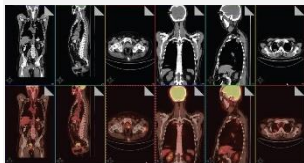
Whole body positron emission tomography/computed tomography (PET/CT) coronal and lateral images and transaxial images of pelvis show abnormal focal fluorine-18-fluorodeoxyglucose (FDG) uptake in prostate. PET/CT coronal images of thorax show abnormal focal FDG uptake in right upper pole of lung. (The image above is contrast enhanced CT and the one below is corresponding fused PET/CT)
